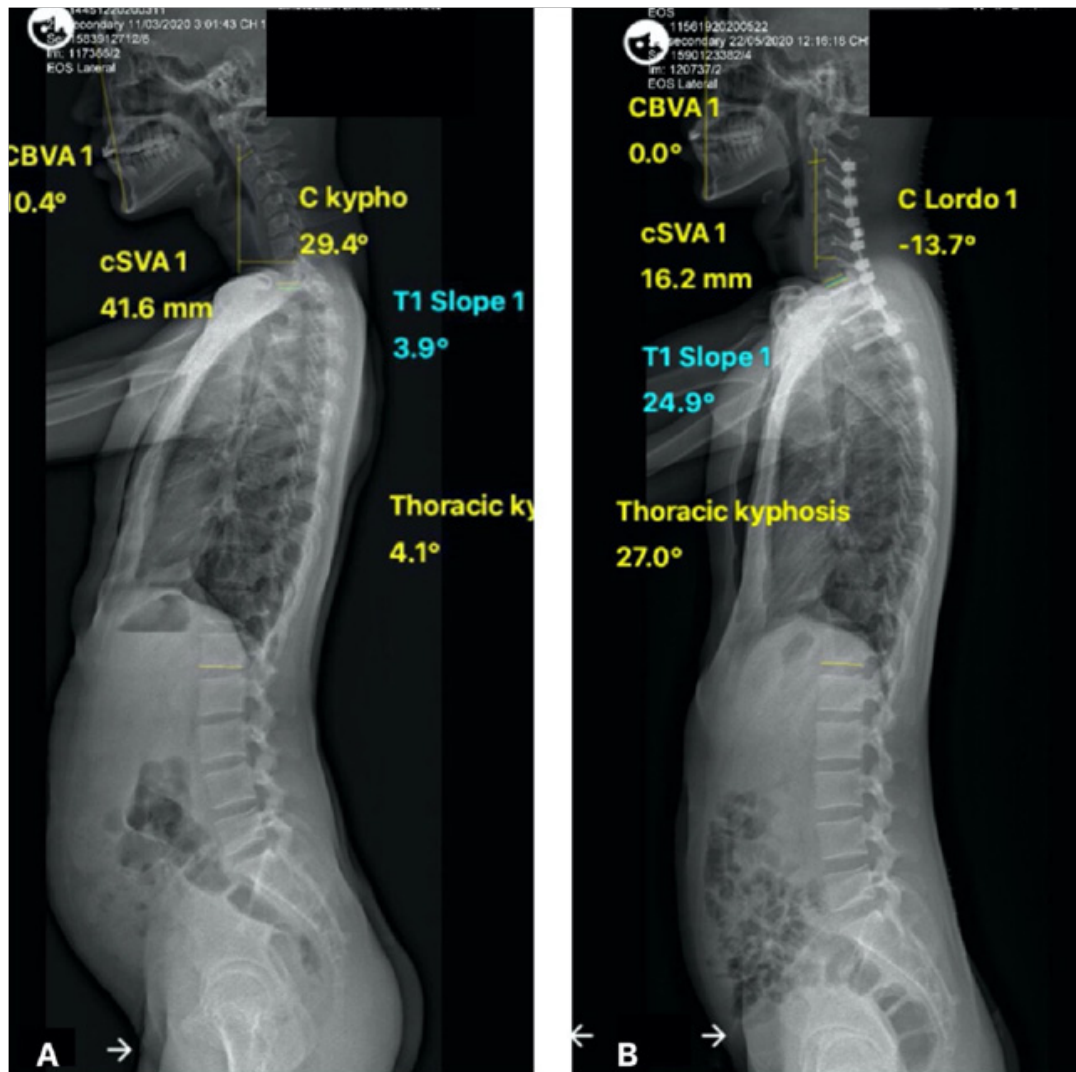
Comparison between preop and postop full spine Xrays: preop Xray (A) with flexed cervical deformity and flattening of thoracic spine as compensation, postoperative Xray (B) with optimal sagittal balance parameters.
